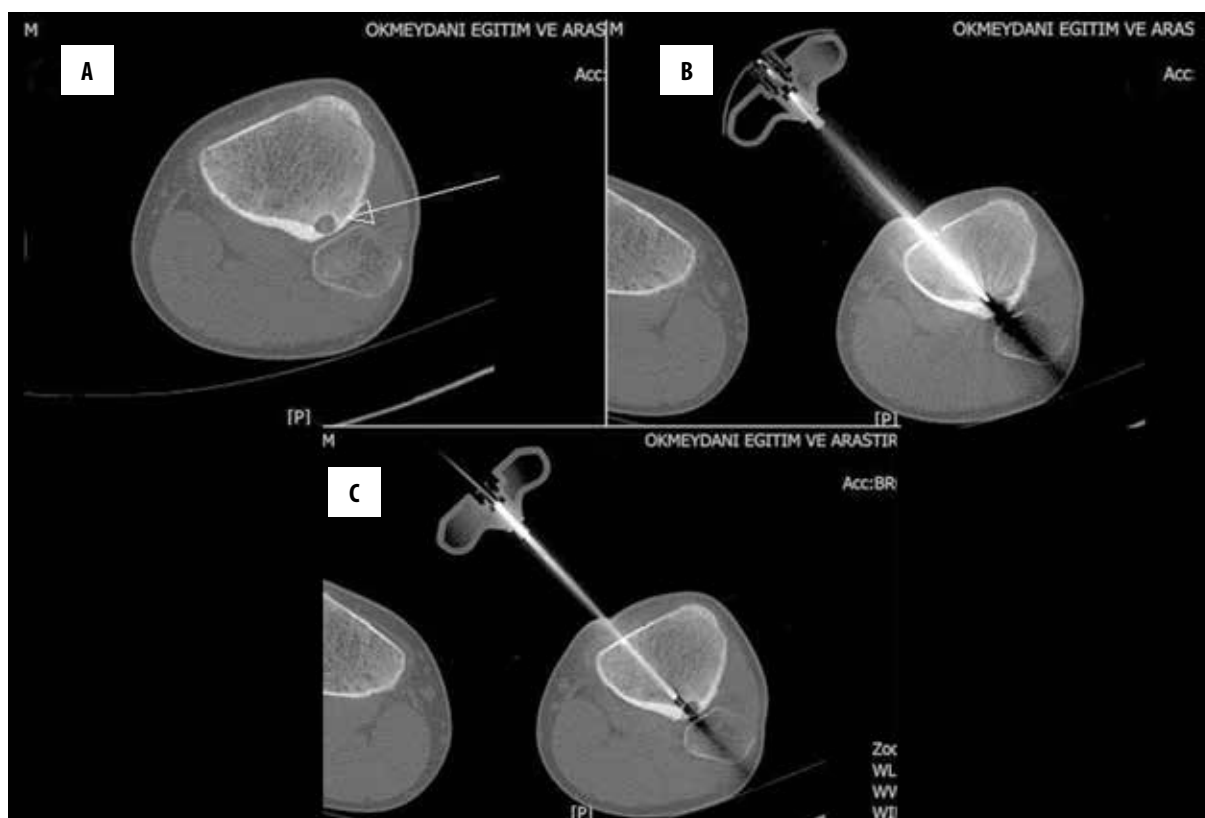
Ablation of an osteoid osteoma of the left proximal metaphyseal tibia. (A) CT scan demonstrates the nidus [arrow] of the osteoid osteoma. (B) During ablation procedure the tiny RF ablation probe being inserted into the nidus through a needle. (C) After the procedure.
